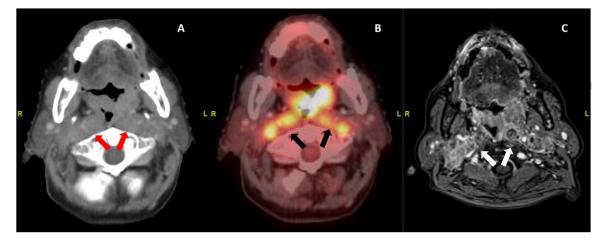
Differential assessment of RPN from primary tumor on axial sections of CECT (left, red arrows), PET-MTV30 (mid, black arrows), and MR (right, white arrows). Regional nodal metastasis to medial retropharyngeal lymph node was better differentiated from primary tumor on T1-contrast MRI than CECT. Although PET-MTV30 is showing FDG uptake in left and right RPNs in addition to primary tumor, it is feasible to identify RPN separately from the tumor. *Abbreviations:* CECT = contrast-enhanced computed tomography; MRI = magnetic resonance imaging; PET-MTV30 = metabolic tumor volume 30% intensity of maximum standardized uptake value on positron emission tomography; RPN = retropharyngeal node. (A color version of this figure is available at 10.1016/j.adro.2024.101453.)
